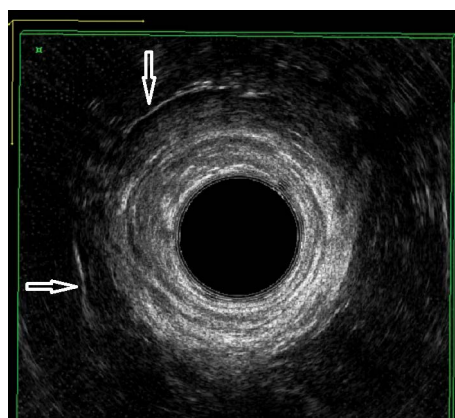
Endoanal ultrasound post-surgery. Arrows indicate the circular suture
